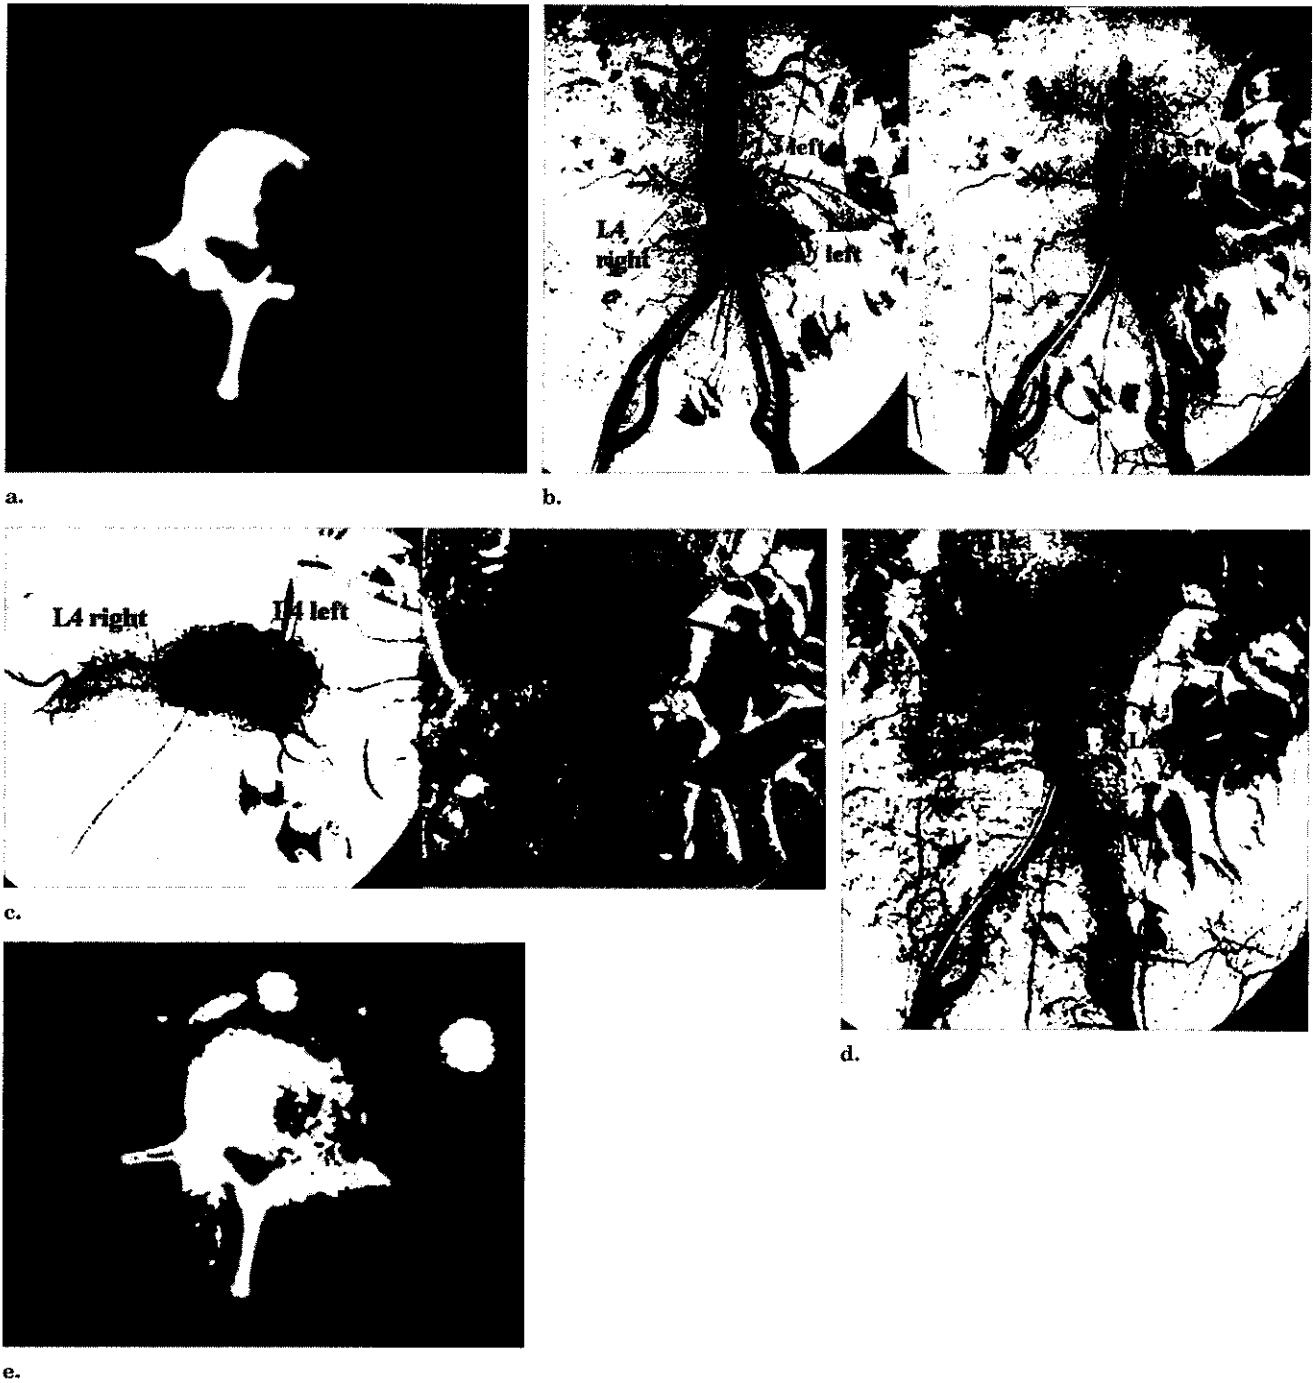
(a) Axial computed tomography (CT) scan of the lumbar spine of a 40-year-old man with metastatic renal cell carcinoma at the L4 vertebra. (b) Early (left) and late (right) phase digital subtraction aortography shows a hypervascular lesion at L4 level. The feeding vessels originate from bilateral L4 arteries and the left L3 artery. (c) Selective embolization through bilateral L4 arteries (left) and left L3 artery (right) was done. (d) Late phase digital subtraction aortography after embolization shows complete occlusion of feeding vessels to the hypervascular lesion. (e) At 6 months, axial CT scan at the same level shows tumor size reduction and ossification.
